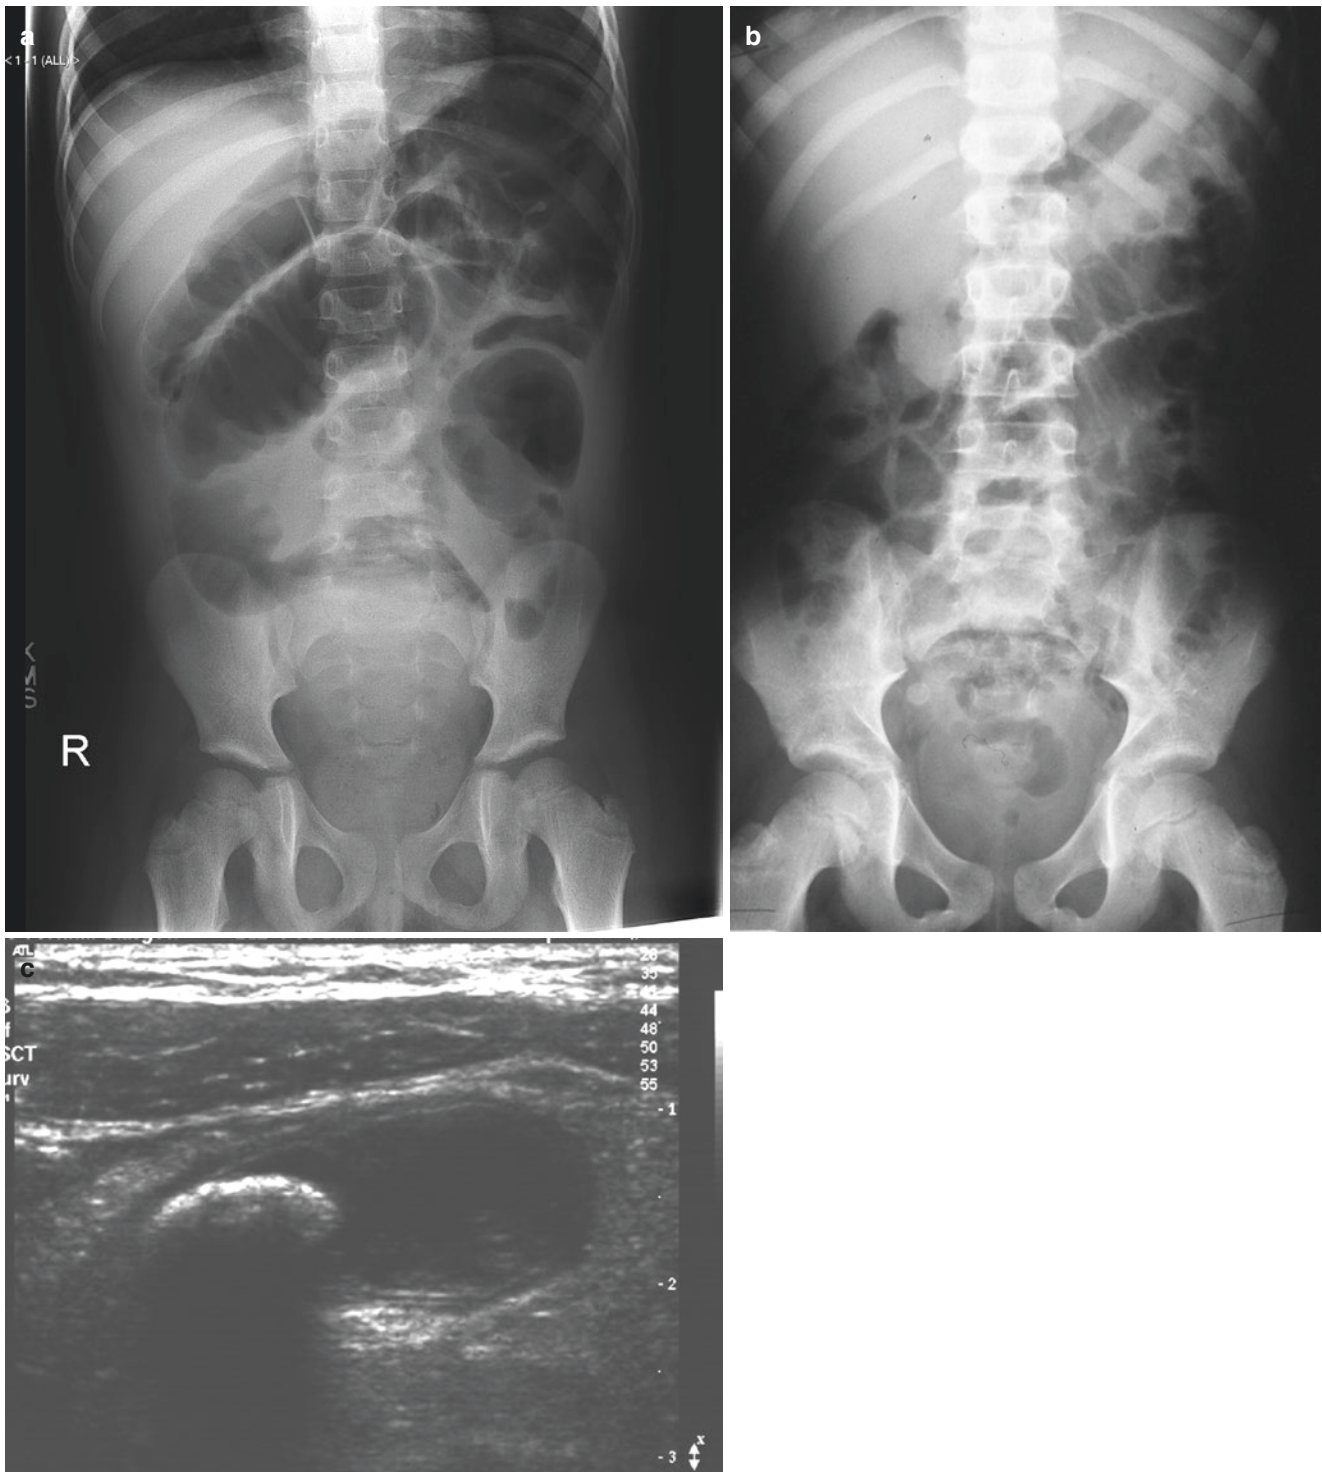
(a) Acute appendicitis. Plain X-ray showing small bowel dilated loops. (b) Appendicitis. Plain X-ray showing faecolith in right iliac fossa. (c) Ultrasound in acute appendicitis
